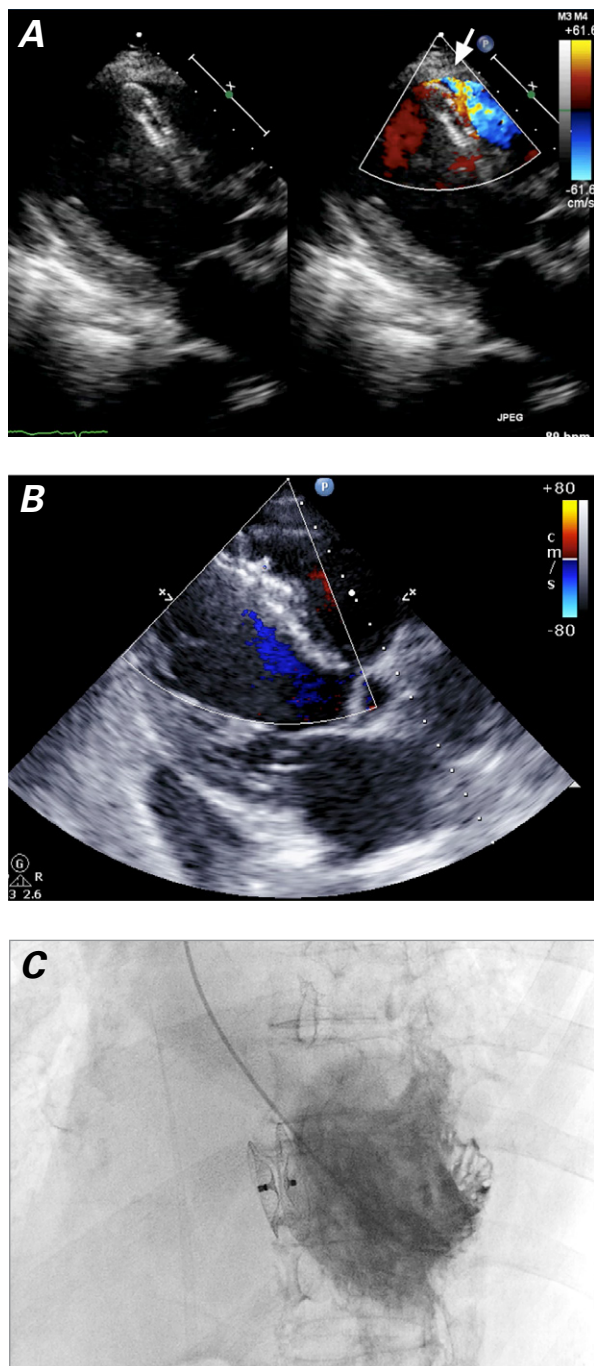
Patient 1. A) Transthoracic echocardiogram (color-flow Doppler mode, apical long-axis view) on postoperative day 2 shows increasing left-to-right shunt flow (peak velocity, 2 m/s) across the ventricular septum through the lower half of the AMPLATZER occluder (arrow). At 4 months, a B) transthoracic echocardiogram (apical long-axis view) and C) left ventriculogram show no shunting.
